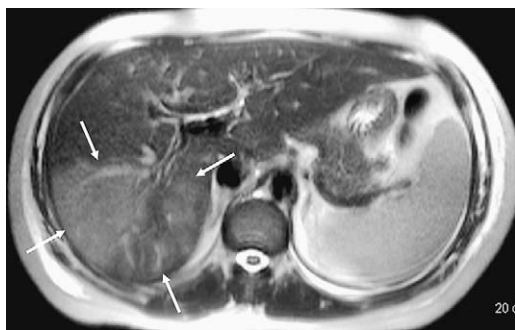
34-year-old G1P0 with pre-eclampsia and HELLP and transaminases >1000. Axial T2-weighted MRI of the liver demonstrates geographic increased signal intensity in the posterior right hepatic lobe (arrows) due to hepatic congestion.
